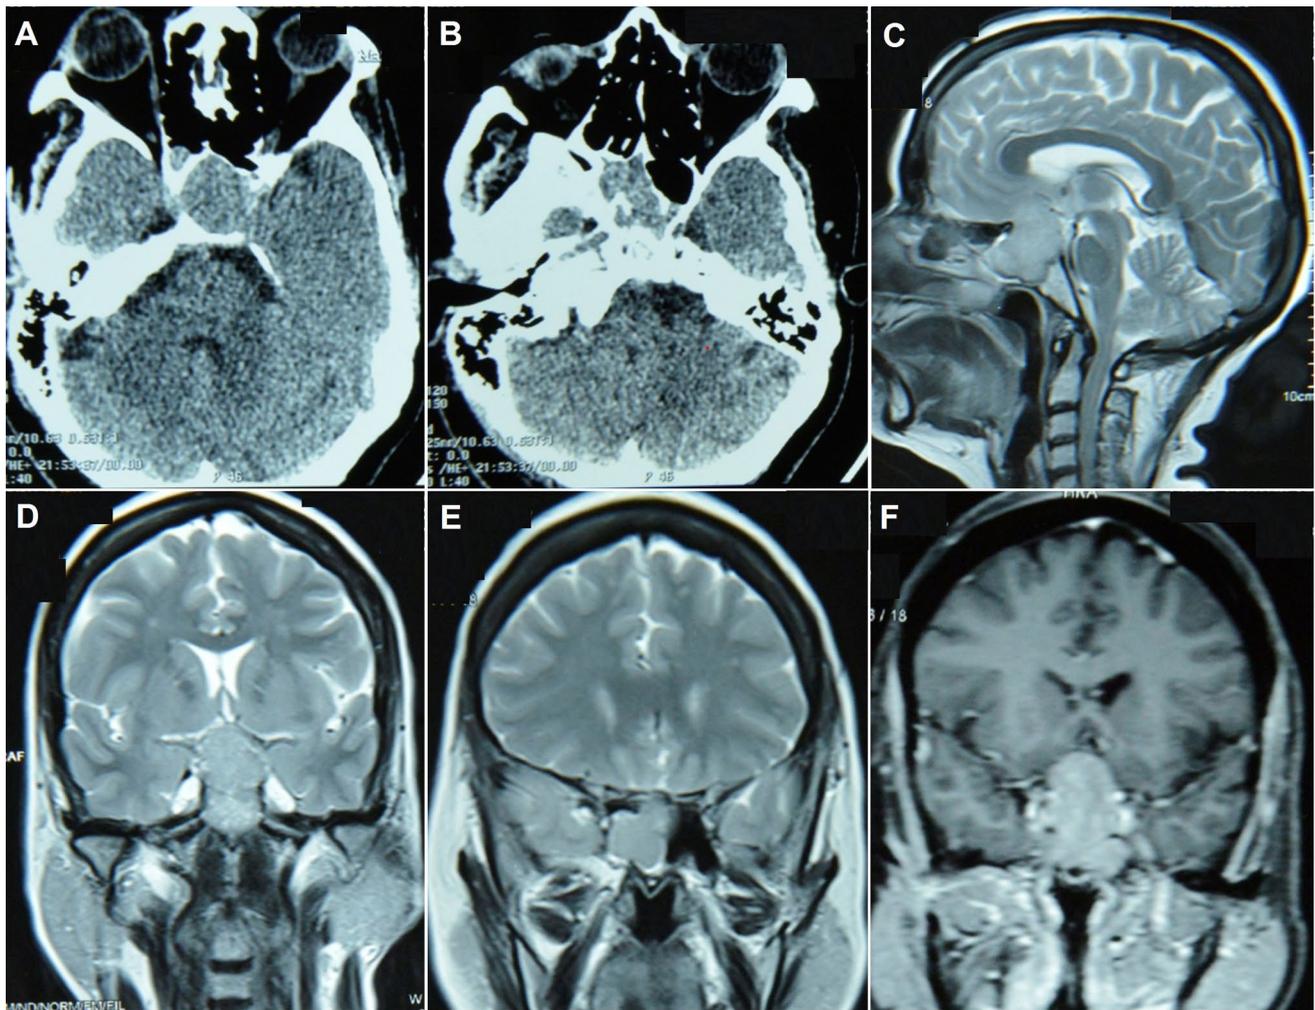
a, b CT images showing expansion of sella with tumor eroding the floor into the sphenoid sinus; c mid sagittal T2 MR image showing sellar/suprasellar *iso*-hyperintense mass eroding the floor and upper clivus; d, e coronal T2 MR images showing sellar/suprasellar
